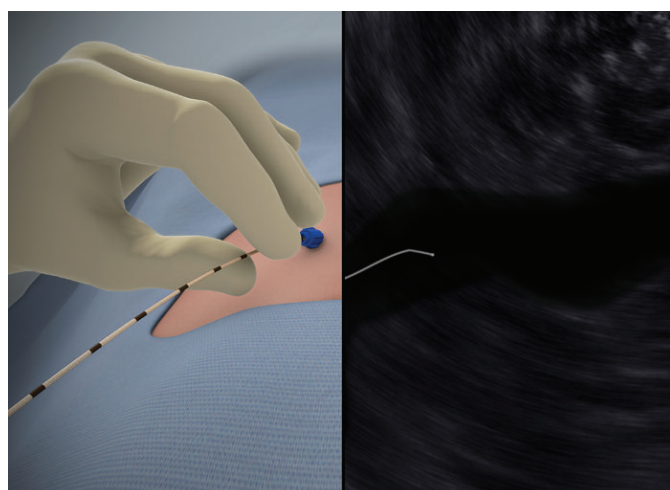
After insertion under local anesthesia, the ClariVein® catheter is placed near the saphenofemoral junction under ultrasound guidance (courtesy of Vascular Insights LLC, Quincy, MA).
